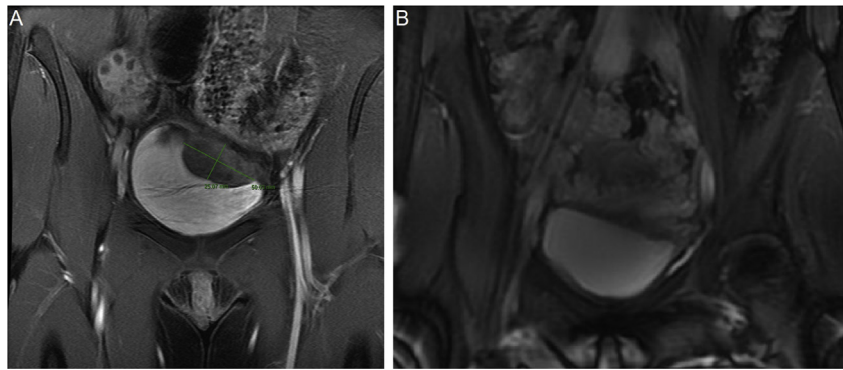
MRI - Preoperative MRI (A) shows a 5 cm vascular mass with intra- and extraluminal components, without any arterial enhancing component. Postoperative MRI (B) obtained for gastrointestinal bleeding demonstrates smooth bladder wall without any lesions or filling defects.
